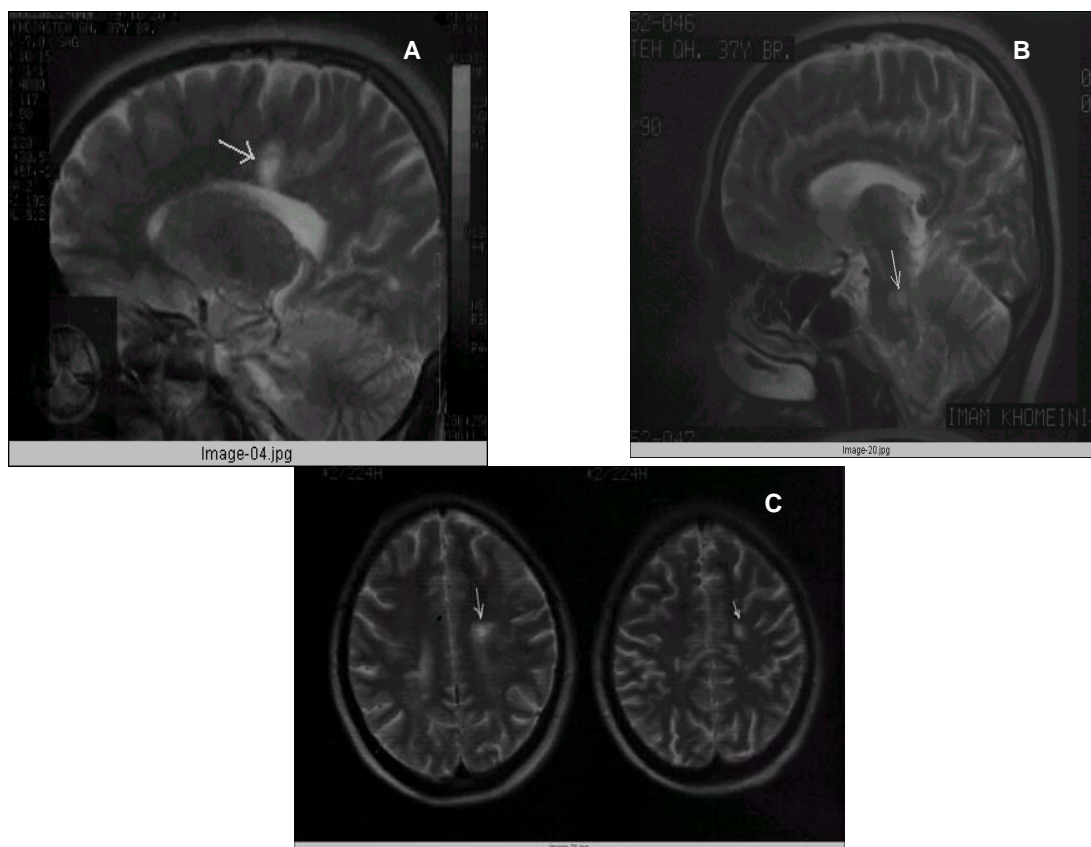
A) T2-weighted MRI showing pericallosal plaques with the pattern of “Dawson fingers”; B) T2-weighted MRI showing a pontine plaque responsible for patient’s symptom; C) T2-weighted MRI showing two periventricular plaques.
